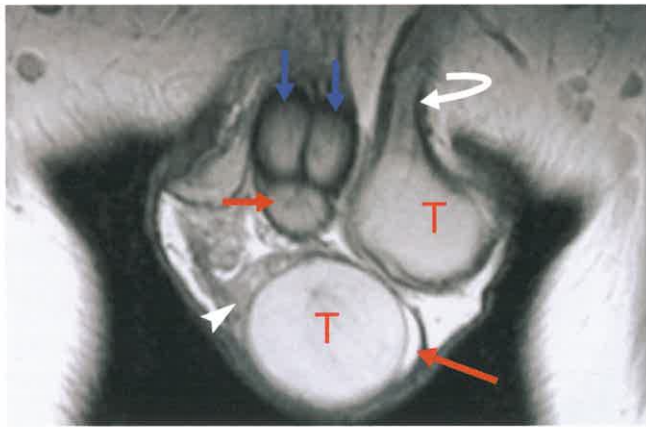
Normal MR Anatomy: Male. Coronal plane T2-weighted MR shows both testes (T) and the penis in cross-section. The testes are high in signal because of their high fluid content. The epididymis (arrowhead) is also high signal on T2WI but less than that of the testes. The left testis is suspended on the spermatic cord (curved arrow). The paired corpora cavernosa (blue arrows) are well demonstrated. The corpus spongiosum (red arrow) contains the urethra. A small amount of fluid (long red arrow) is present between the layers of the tunica vaginalis.
